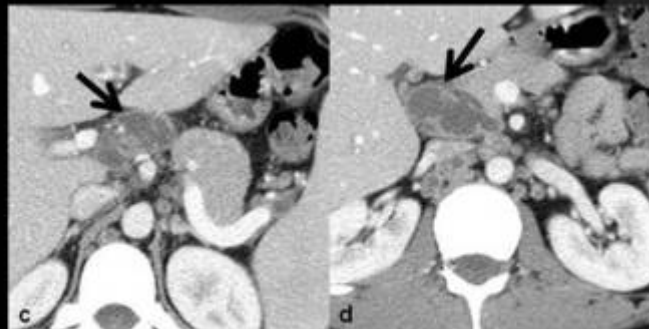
Abdominal CT after iv contrast – axial planes. Lymph nodes enlargement with a low-density center and a peripheral enhancement. a – retrocrural, b- lombo-aortic, c and d- peripancreatic lymphadenopathy
